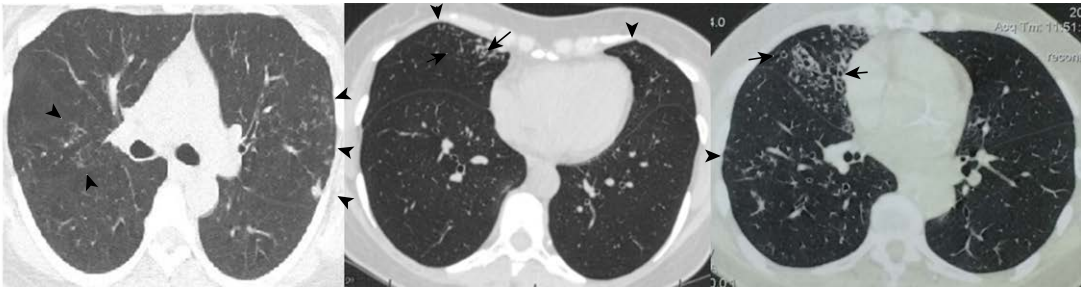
Common chest CT findings for Lady Windermere syndrome. Note centrilobular nodules with a linear branching pattern (tree-in-bud pattern; arrowheads) and bronchiectasis, the latter occurring predominantly in the middle lobe and lingula (arrows). The nodules in the middle of the secondary pulmonary lobule occur where the bronchioles are small in diameter, without cartilaginous support, and with relatively more developed musculature than that of the bronchi (an area theoretically subject to an earlier complication of neuromuscular damage).
